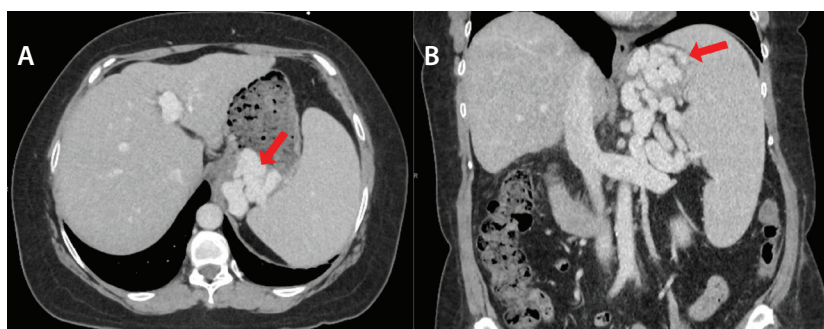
CT showing axial view (A) and coronal view (B) of gastric varices (red arrows) before treatment.
